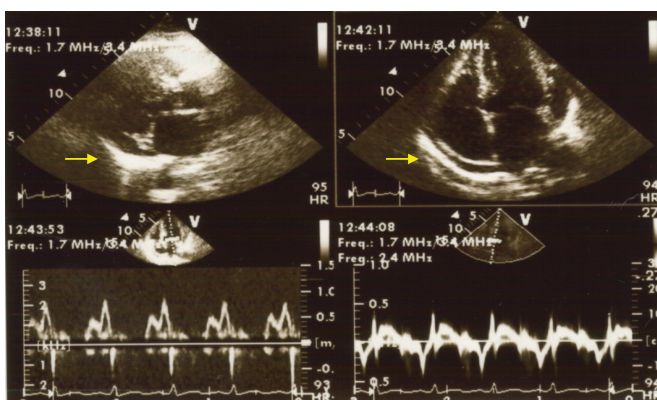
Echocardiography showing a circumcardiac pericardial effusion (yellow arrow) in parasternal long axis (left) and apical 4 chamber (right).
